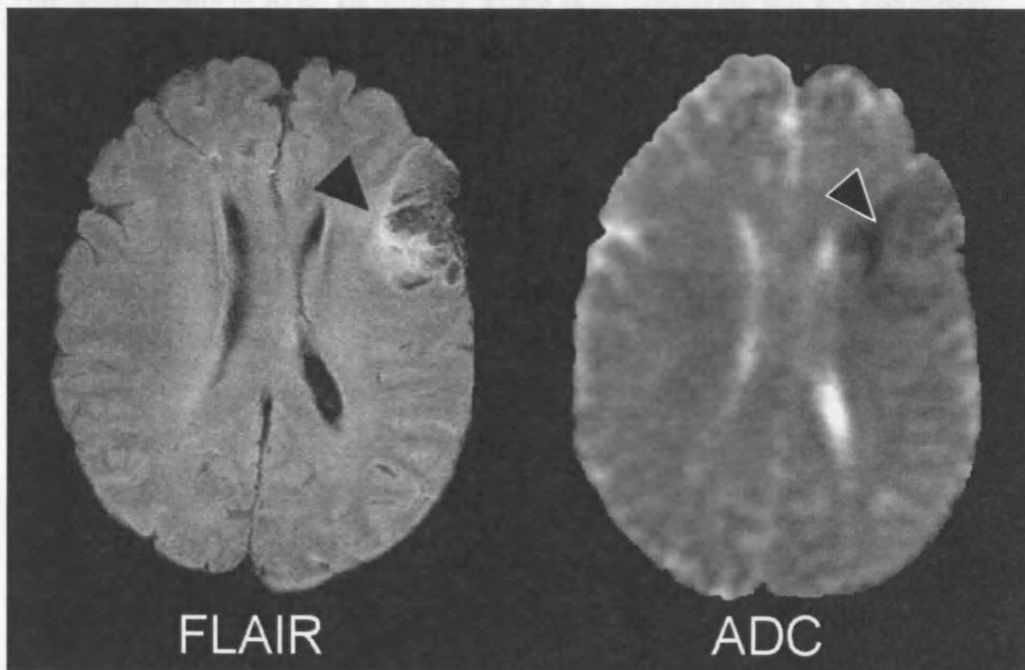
FLAIR hyperintensity associated with reduced ADC values
